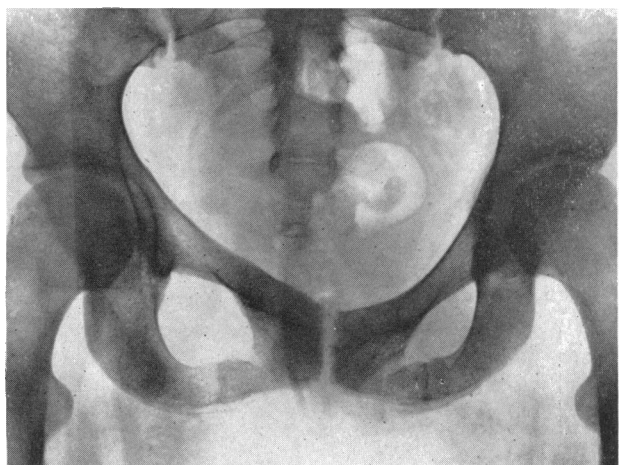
Radiograph of pelvis on March 14, 1955, also showing calcification of Looser's zones after treatment.
